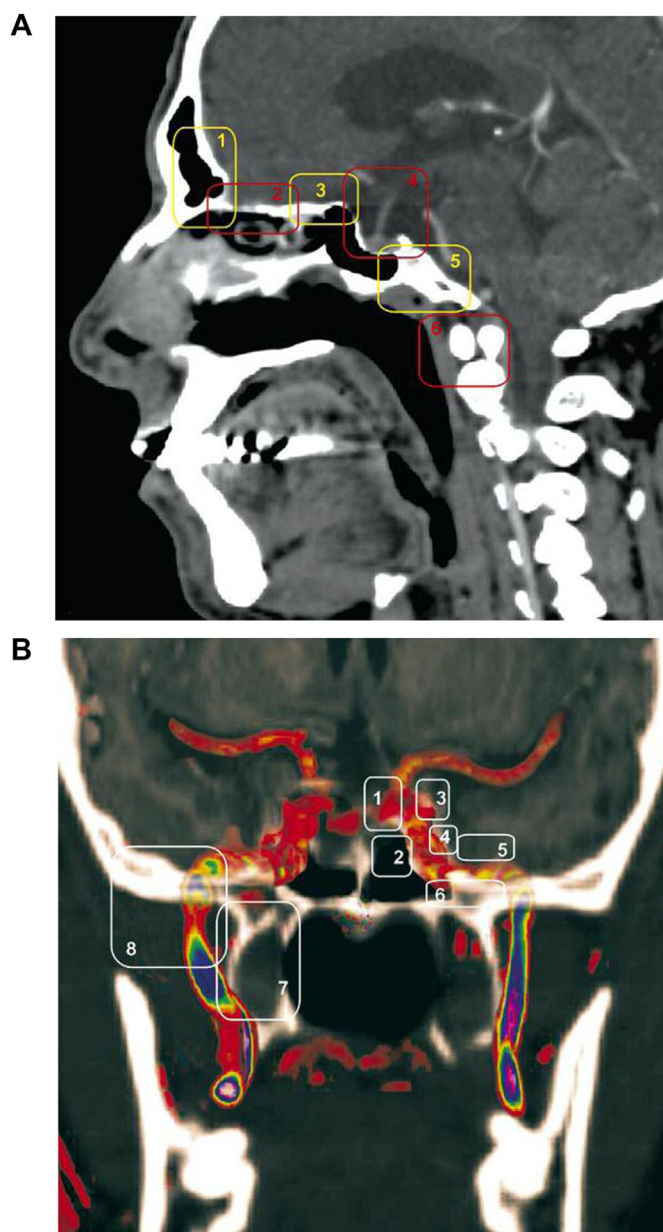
Picture obtained by merging MR and CT images to show locations of extended transnasal endoscopic approaches. (A) Sagittal plane: 1) frontal sinusotomy according to Draf, 2) transcribriform plate approach, 3) transplanum approach, 4) transsellar approach, 5) transclival approach, 6) transodontoid approach. (B) Coronal plane – scan through the pterygoid processes: 1) medial cavernous sinus approach, 2) petrous apex approach, 3) lateral cavernous sinus approach, 4) Meckel cave approach, 5) suprapetrous approach, 6) infrapetrous approach, 7) sphenopalatine fossa approach, 8) infratemporal fossa approach [13]. Reprinted with permission from: Transnasal endoscopic approaches to the cranial base. Tomasz Lyson, Andrzej Siesekiewicz, Robert Rutkowski, Jan Kochanowicz, Grzegorz Turek, Marek Rogowski, Zenon Mariak. *Neurologia i Neurochirurgia Polska* 2013; 47, 1: 63–73. <https://doi.org/10.5114/ninp.2012.31474>. https://journals.viamedica.pl/neurologia_neurochirurgia_polska/article/view/60868. Copyright © 2013 by Polish Neurological Society.
